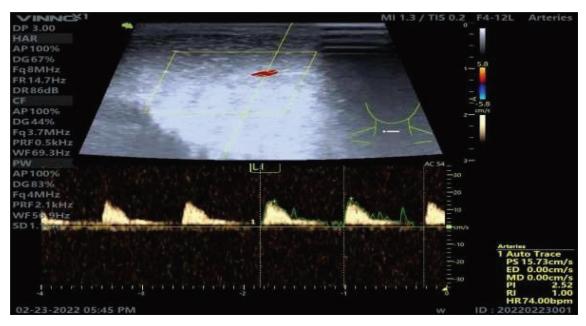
Penile artery Doppler for male case aged 65 years old hypertensive for 7 yr. Coronary angiography showed severe double vessel affection. ILFE-5 score was 10. On penile artery Doppler; PSV was 15.73 cm/s.
